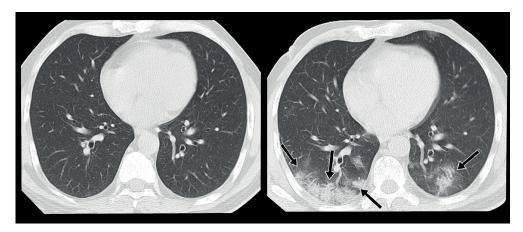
A 50-year-old male patient. Initial chest CT shows no disease findings. Follow-up chest CT demonstrates bilateral peripheral ground-glass densities and consolidations (black arrows).
